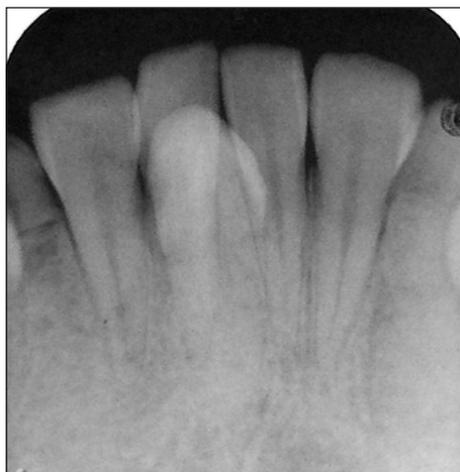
A periapical radiograph.
